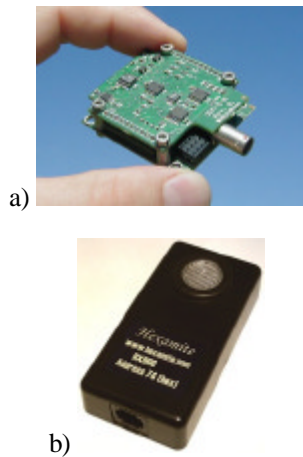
a) Inertial sensor devices manufactured by Microstrain, Inc. and b) Ultrasonic sensor device manufactured by Hexamite, Inc.
